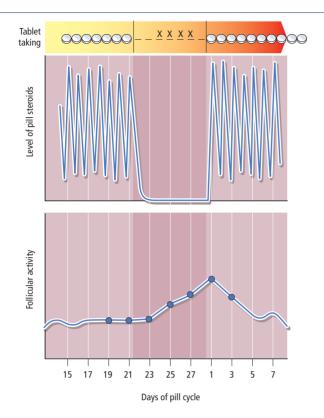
Steroid levels and follicular activity during monocyclic use of the combined oral contraceptive. The days of pill-taking are indicated at the top by small pill symbols, while the pill-free days are dashed. 'X' indicates the days of withdrawal bleeding. The profile of synthetic steroids in the blood (upper panel) reflects the episodic (daily) taking of the pill. Levels fall rapidly when pill-taking ceases. The lower panel shows follicular activity measurable by ultrasound scan (see Figure 15.11) and reflected in the output of endogenous steroids. Activity is low while the pill is taken, but note how rapidly follicles develop when pill-taking ceases, so reducing negative feedback and leading to rising gonadotrophin output. Resumption of pill-taking leads to immediate suppression. Note that a failure to resume pill-taking on time leaves a woman potentially vulnerable to ovulation and pregnancy.
